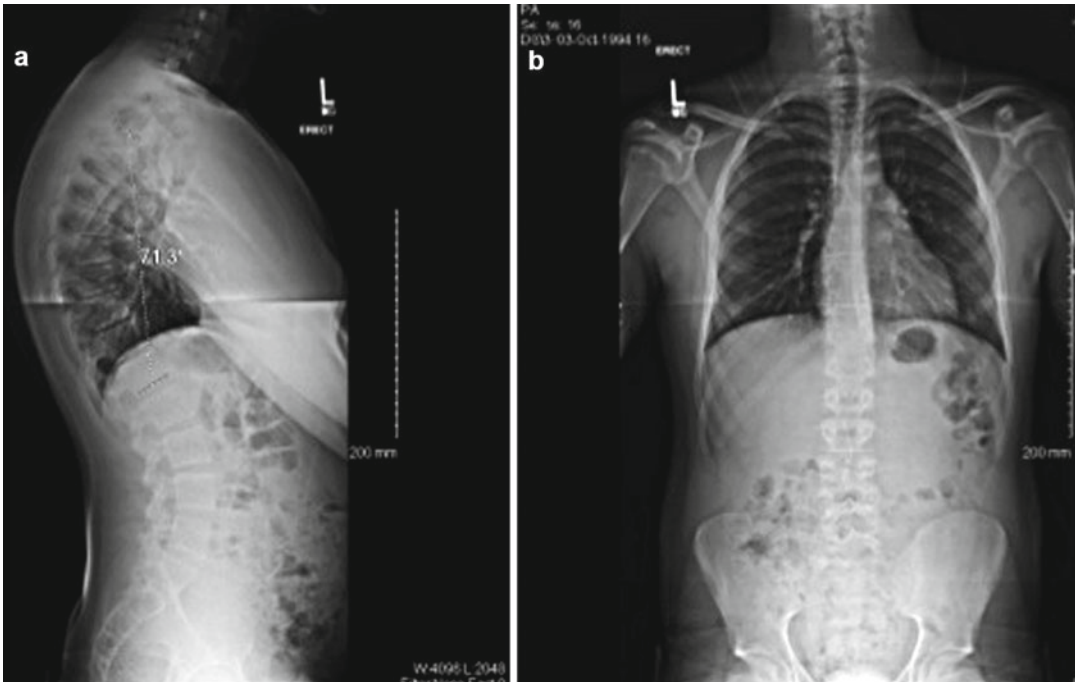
(a) Standing lateral radiograph showing the rigid, fixed thoracic kyphosis centered at T9, measuring 71°. (b) Standing PA radiograph displaying no scoliosis in a 14-year-old boy
